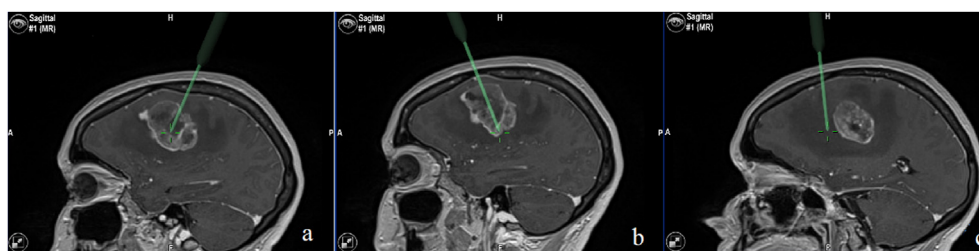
MRI of a patient with glioblastoma. The images were derived from an intraoperative navigation system and show the necrotic (a) and the enhancing tumor areas (b), in which the measurements were performed. The corresponding resistivity values = 2.8 and 4.5 Ω *m, respectively. The measurement was also performed in the peritumoral edema (c). The calculated resistivity value = 8.3 Ω *m.
